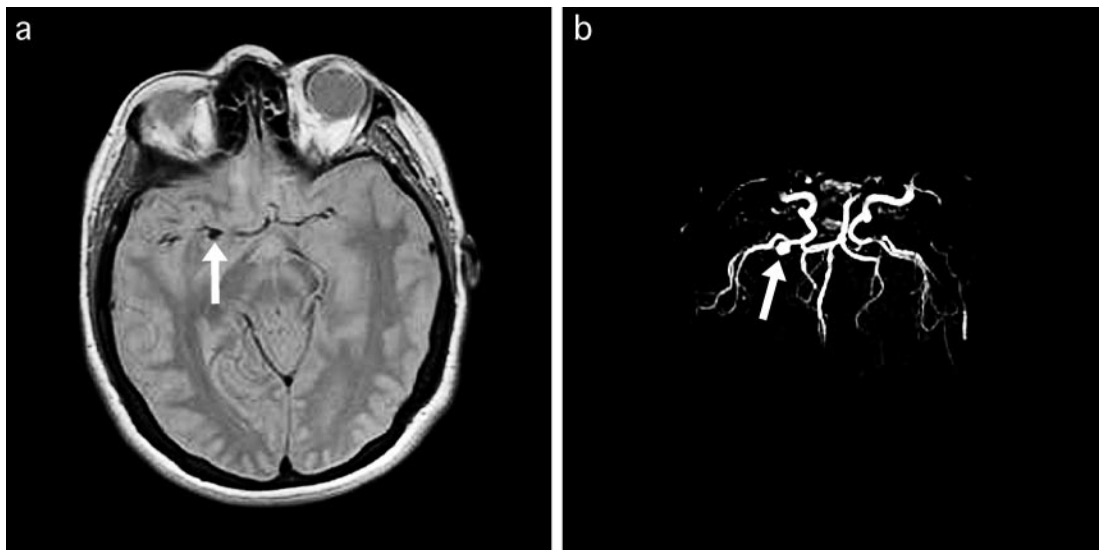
Middle cerebral artery aneurysm. A: Routine proton density MR image reveals an area of abnormal flow void along the horizontal portion of the right middle cerebral artery (arrow). B: Subsequent MR angiography reveals an approximately 7 mm aneurysm of the middle cerebral artery (arrow).
